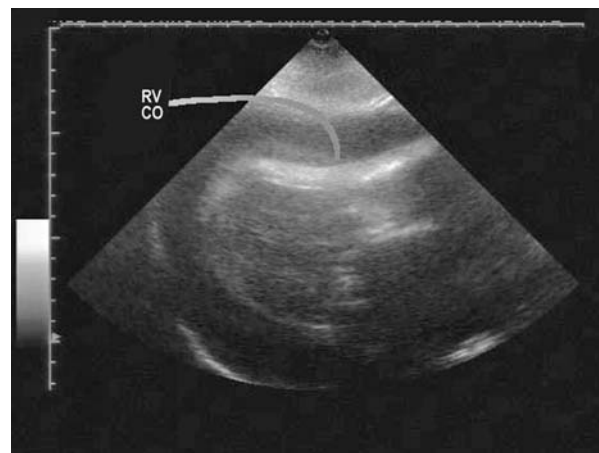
Subcostal echocardiographic image of pericardial tamponade: the echo-free space (representing pericardial fluid) surrounding the heart is more than 10 mm deep in front of the right ventricle and beyond the left ventricle. Note the compression of the right ventricle in diastole.
